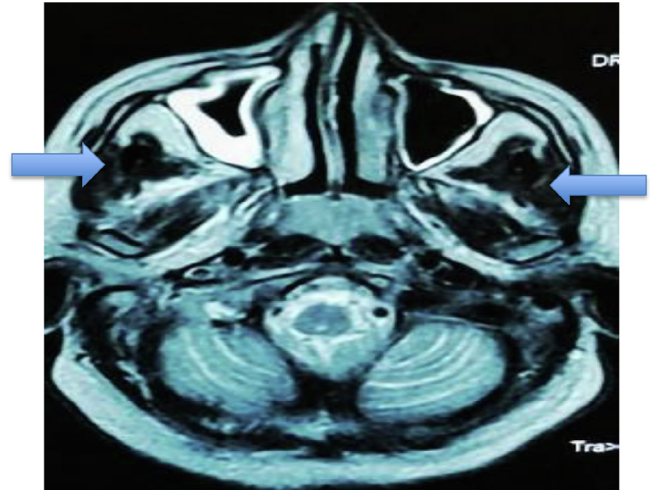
MRI brain with contrast suggested muco-inflammatory changes at bilateral maxillary, right ethmoid and frontal sinuses (arrows).
